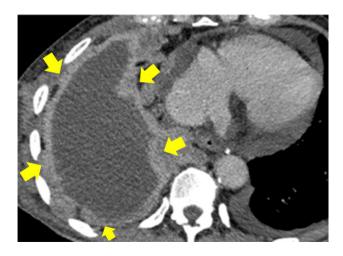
A 70-year-old man with squamous cell lung cancer and right pleural metastasisstandard reconstruction chest CT images show right pleural effusion with subadjacent irregular pleural thickening along the right hemithorax (arrows).
